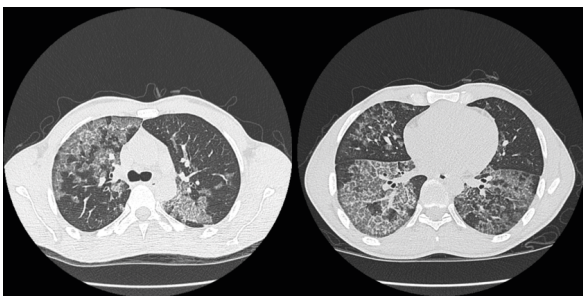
High-resolution computed tomography (HRCT) of the chest during hospitalization, before the procedure: ground-glass opacities with diffuse distribution, with thickened interlobular septa (mosaic paving pattern). (source: own author)
